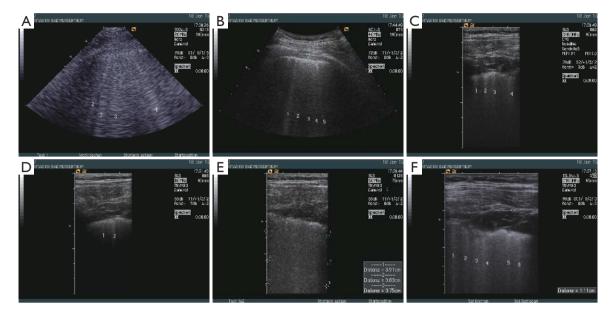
The influence of ultrasound transducers and transducer frequency on BLA visualization was examined in a patient with mixed lung fibrosis and edema and focal pleural irregularities. The examinations were performed using Acuson Sequoia with different multifrequency transducers, 3V2c-S (cardiac), 4C1-S (curved array abdominal), 8L5 (linear), 15L8w-S (linear). The images demonstrate that the focal pleural irregularity was only detected using the high frequency probes, which might influence the imaging characteristics and accompanying signs in BLA patterns. The sequence demonstrates that not all transducers show the same findings. Influencing factors were the transducer itself, frequency used, harmonic imaging (HI), depth penetration, focus zone. The 3V2c-S (2 MHz) (A) and 4C1-S (4 MHz) (B) transducers showed multiple BLA indicating both fibrosis and edema. The amount of BLA and the surrounding artefacts were different. Multiple BLA were detected using 8.0 MHz with harmonic imaging (C) and less without harmonic (D). The "sound of lung water" (pulmonary edema) is best shown by 8L5 using 5.0 MHz (E). The 15L8w-S transducer revealed multiple BLA with 10.0 MHz (F). BLA, B-line artifact.
